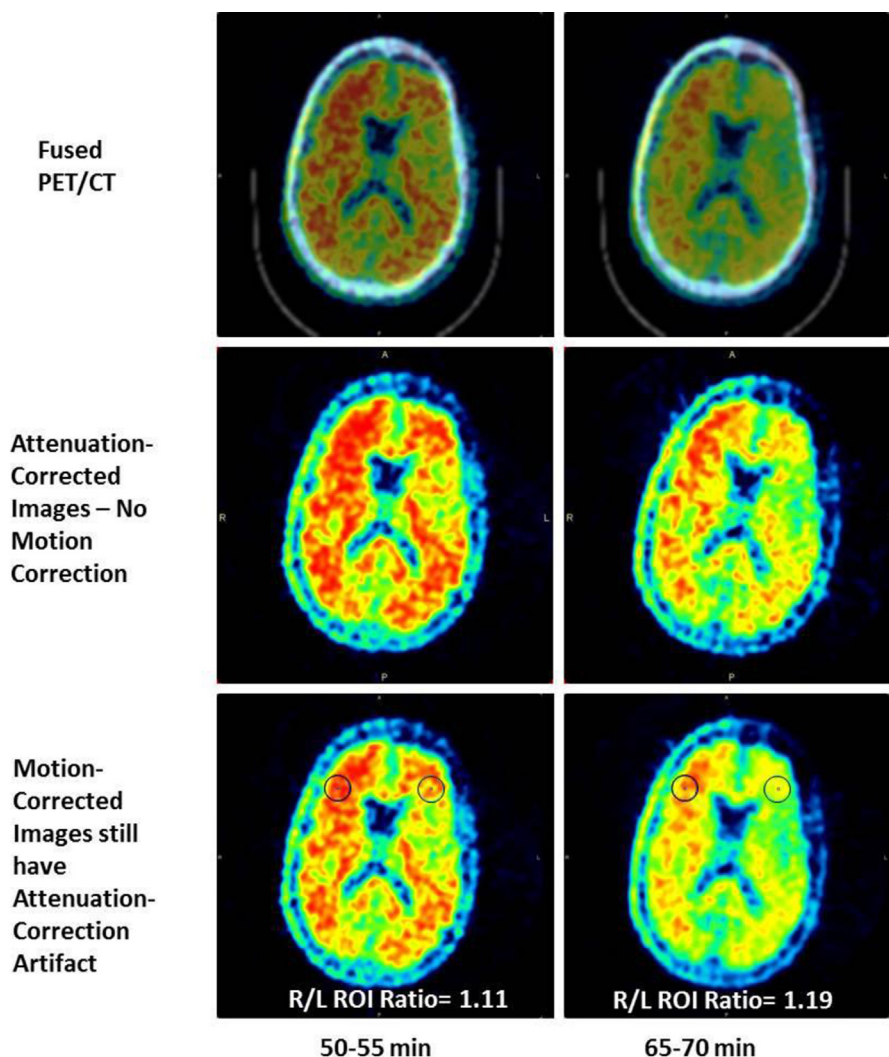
Subject motion between acquisition frames. Examples of a PET/CT scan with significant motion and artifacts due to attenuation correction. Fused data set (top) shows moderate PET/CT misregistration already apparent during the first 5-minute frame (left column), and severe errors by the fourth frame (right column). In this case (middle row), the correction biases are visually evident even after motion correction by registering all time frames to the first (bottom row), the attenuation-correction error can induce large differences in quantification, as demonstrated by the visible difference in signal on the right and left sides of the brain and reflected in the ratios of regional uptake in simple circular ROIs on the bottom of the images.
